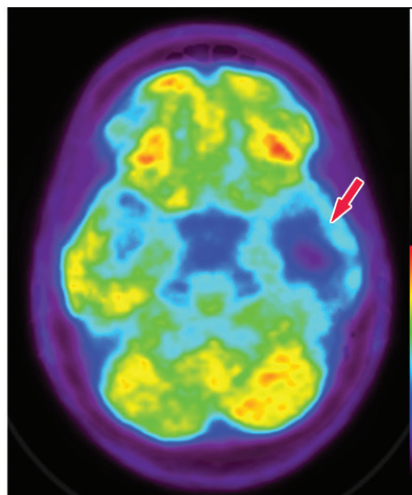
Various causes of cognitive impairment. (a) Coronal T2-weighted MR image in a patient with progressive memory loss shows an extra-axial mass (arrow) with broad-based dural attachment, a finding most compatible with meningioma. Note the marked right frontal vasogenic edema and leftward midline shift with transfalxine herniation. (b) Axial contrast material-enhanced T1-weighted MR image in a patient with a 3-month history of progressive cognitive impairment shows a large left frontal lobe, a solid and cystic heterogeneously enhancing parenchymal mass with rightward midline shift, transfalxine herniation, and left ventricular effacement. This was a case of anaplastic oligodendroglioma. (c) Axial ^{18}F -FDG PET image in a patient with mild cognitive impairment shows markedly decreased uptake in the left temporal lobe (arrow). (d) Corresponding axial CT image in the same patient as in c obtained for attenuation correction shows an acute intraparenchymal hematoma (arrow).
